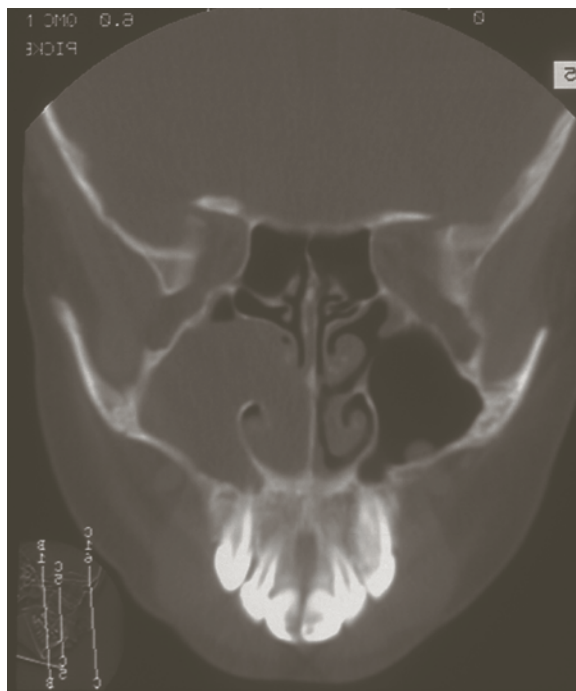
A coronal CT scan showing a right antrochoanal polyp. Note the air above the convex surface of the polyp within the maxillary antrum showing that this is the top of a mucous retention cyst that has prolapsed into the nasal airway
